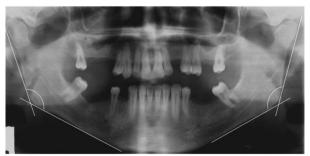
The reference lines and points in measurement of the mandibular angle on the panoramic radiograms.
